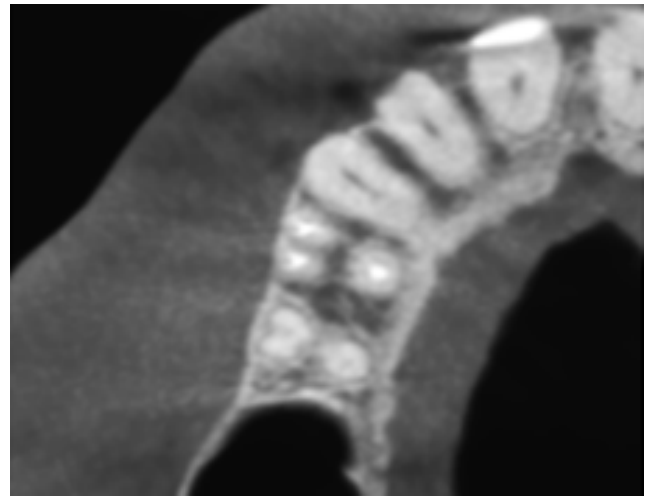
Post op CBCT with three roots and three canals obturated
